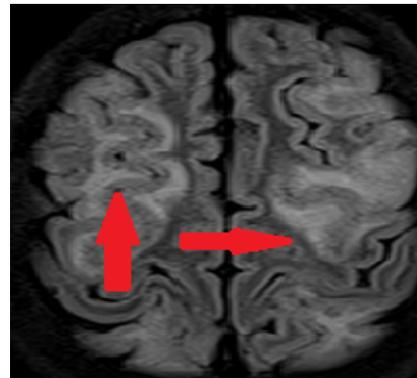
Frontal pattern of PRES – Axial FLAIR images showing hyperintense signal at level of inferior frontal sulcus and lobe on either side (red arrow).
